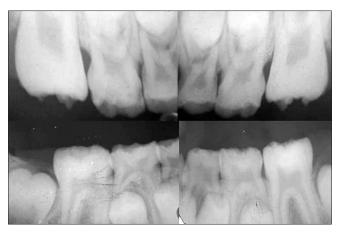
Intraoral periapical radiographic examination of all the four permanent first molars showed external irregular cuspal projections seen on the occlusal third of all permanent first molars. Permanent tooth buds were noticed below the primary molars
